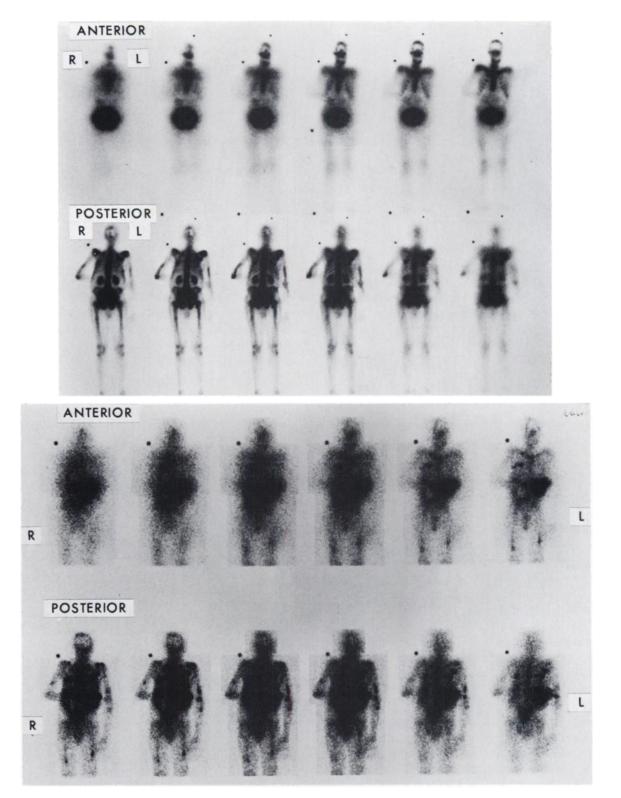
(Top) Multiplane scintigraphic bone scan in patient with multiple myeloma. Note single large abnormality in left upper rib cage posteriorly. (Bottom) Same patient as above. Gallium multiplane study shows multiple focal abnormalities in rib cage and extremities. In addition, note left upper quadrant soft-tissue abnormality later shown to be a plasmacytoma.
